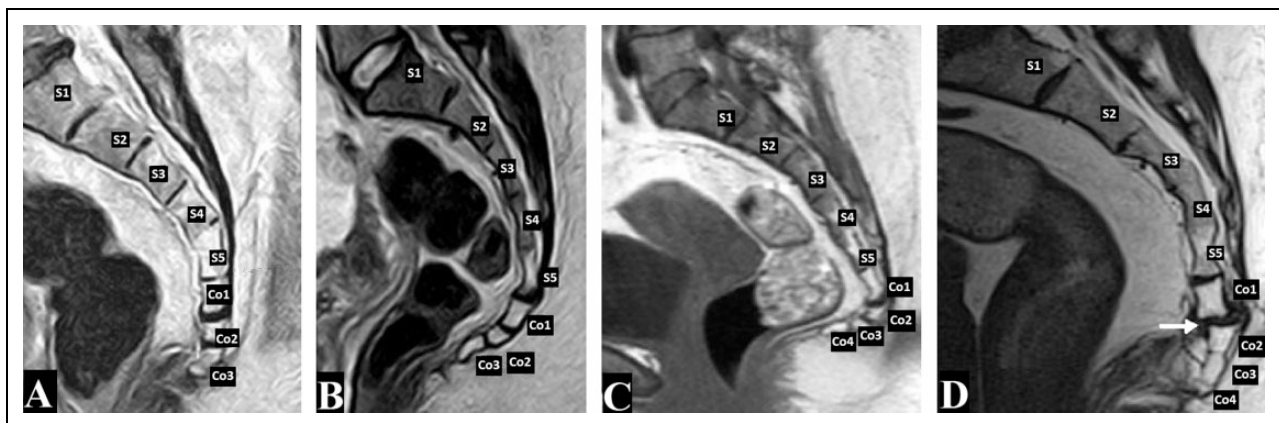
MRI of the sacrococcygeal region showing the coccygeal types: (A) Type I, (B) Type II, (C) Type III, (D) Type IV.
